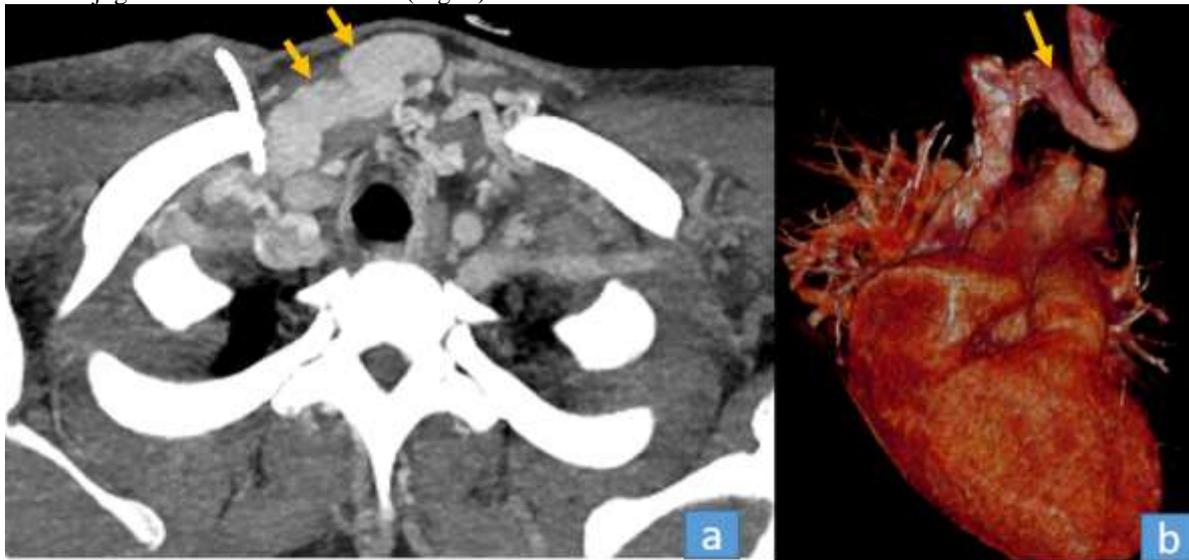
(a) Axial contrast-enhanced MIP CT venography image at the suprasternal notch level and (b) 3D VR image demonstrating a dilated, tortuous right anterior jugular vein draining into the confluence of right external jugular vein. *MIP: Maximum Intensity Projection; VR: Volume Rendering.*
